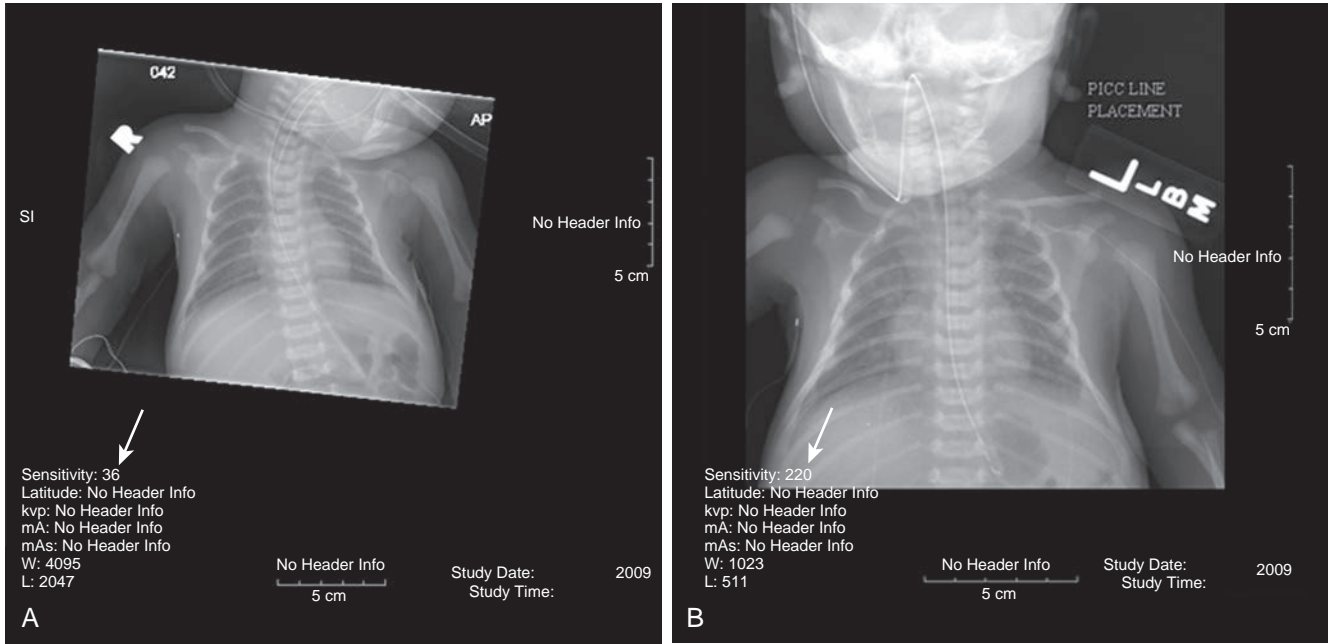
(A) Neonatal chest radiograph has an exposure index (“S” value 39) (arrow) that was very low, indicating a relatively high radiation exposure, which would have rendered this image dark with film screen technology. This radiograph was processed to yield appropriate contrast and brightness. (B) After adjustment to a more appropriate exposure index (“S” value 220) (arrow). The image quality is very similar. The left arm was included because assessment was for percutaneous indwelling central catheter placement. (From Frush DP. *Radiation protection in children undergoing medical imaging*. In Daldrop-Link HE, Gooding CA, eds. *Essentials of Pediatric Radiology*. Cambridge: Cambridge University Press; 2010. Used with permission.)
